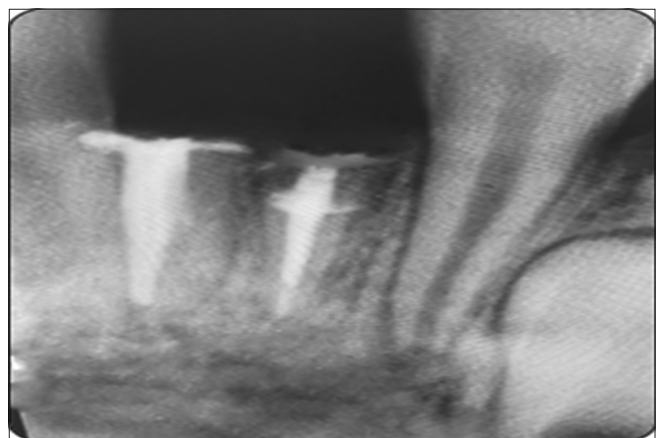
Post-operative radiographic view
